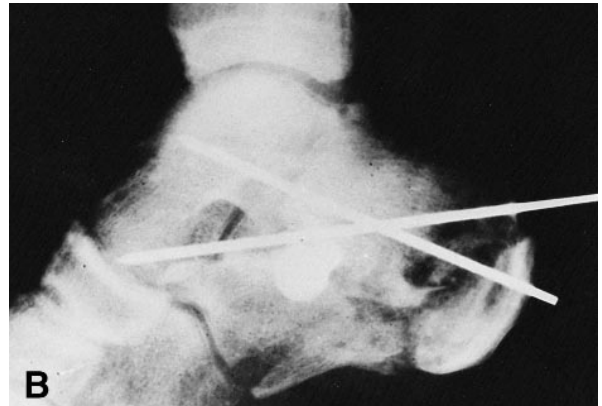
(A, B) Foot condition and preoperative X-ray.
